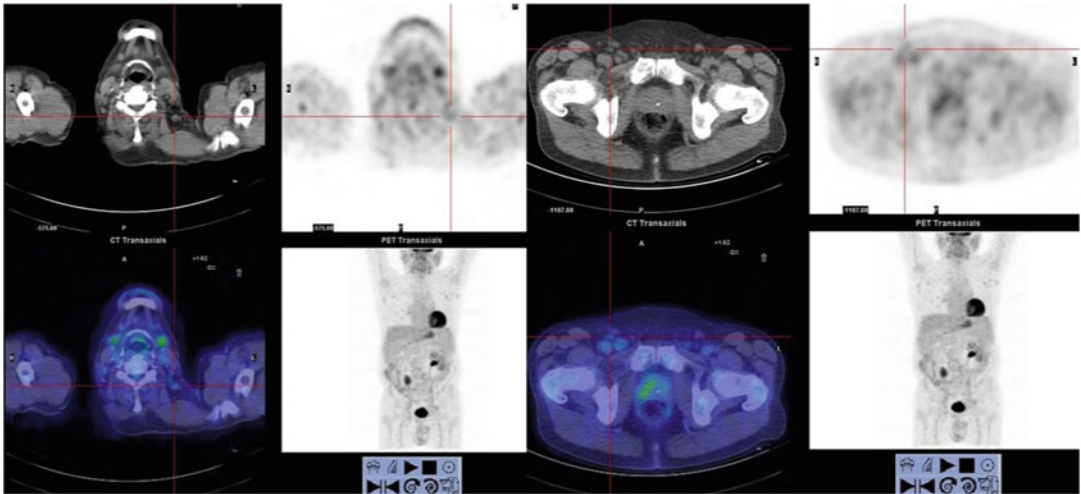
[18F]FDG PET/CT in a patient with marginal zone lymphoma: laterocervical and inguinal lymphnodes that present very low [18F]FDG avidity
